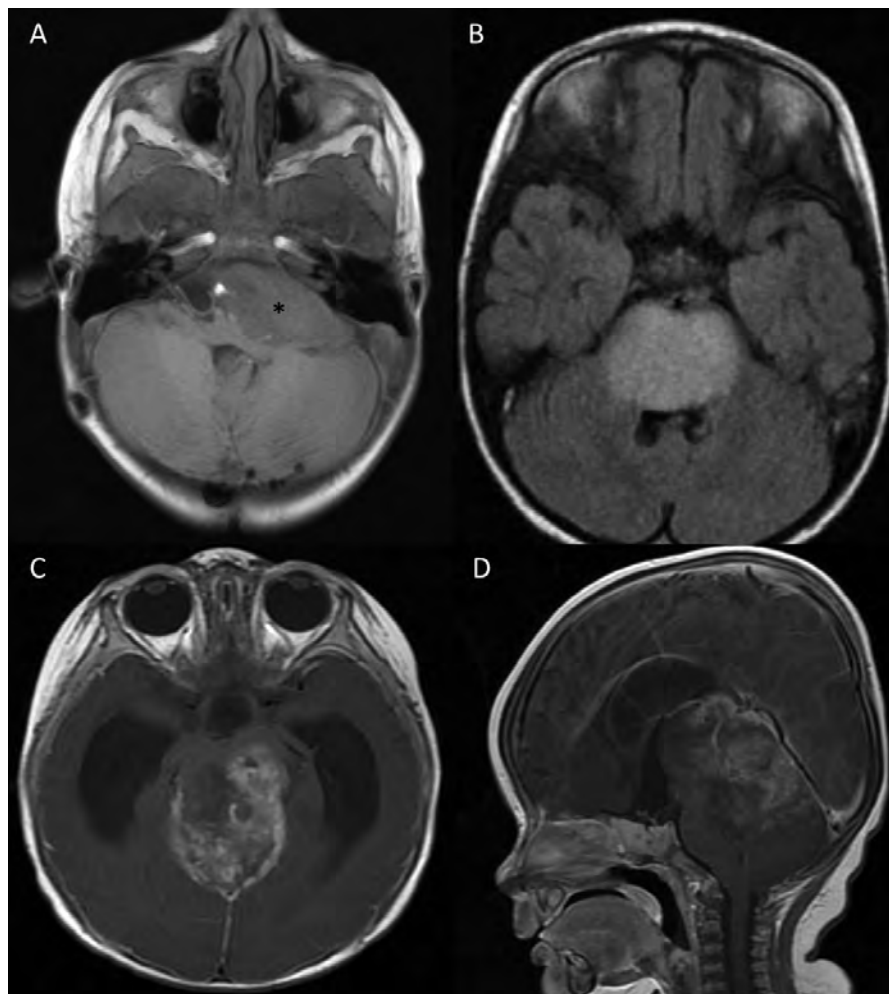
(A) post-contrast MR image demonstrating an ependymoma in the cerebellopontine angle (asterisk); the tumour is hypointense and does not enhance; the brainstem is distorted and rotated to the right; (B) FLAIR image demonstrating a diffuse hyper-intense lesion consistent with a pontine glioma. (C) and (D) post-contrast axial and sagittal MR images of posterior fossa ATRT; the tumour is large and diffuse, involving the cerebellum and brainstem and extends superiorly through the tentorial incisura.
